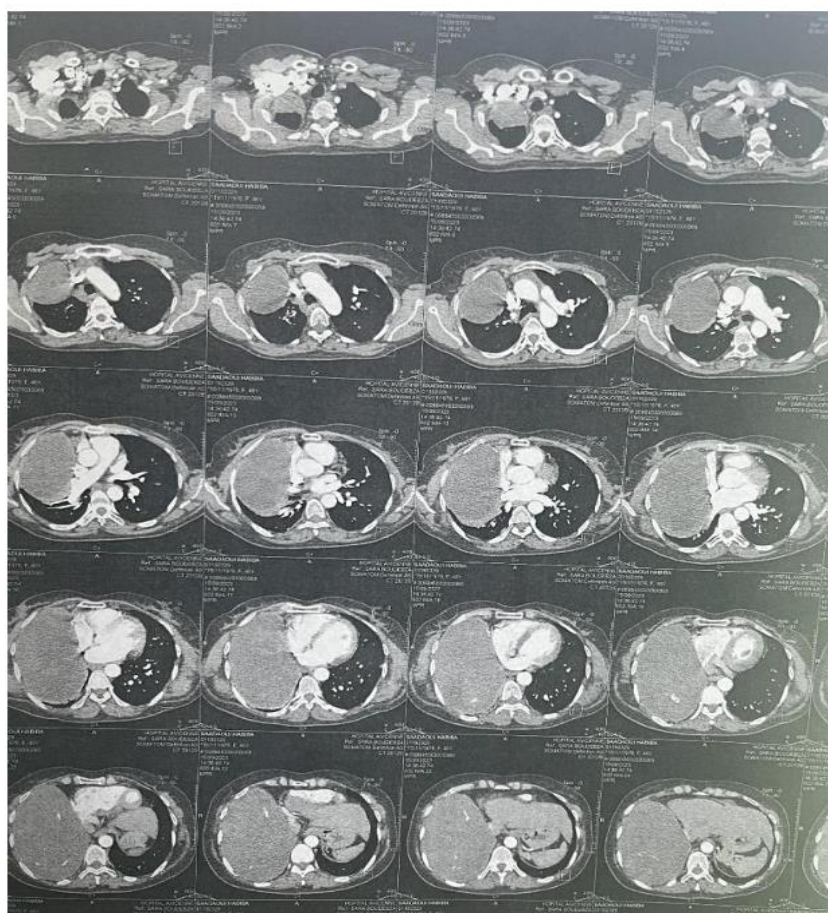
Chest CT reveals a voluminous right pleural mass
